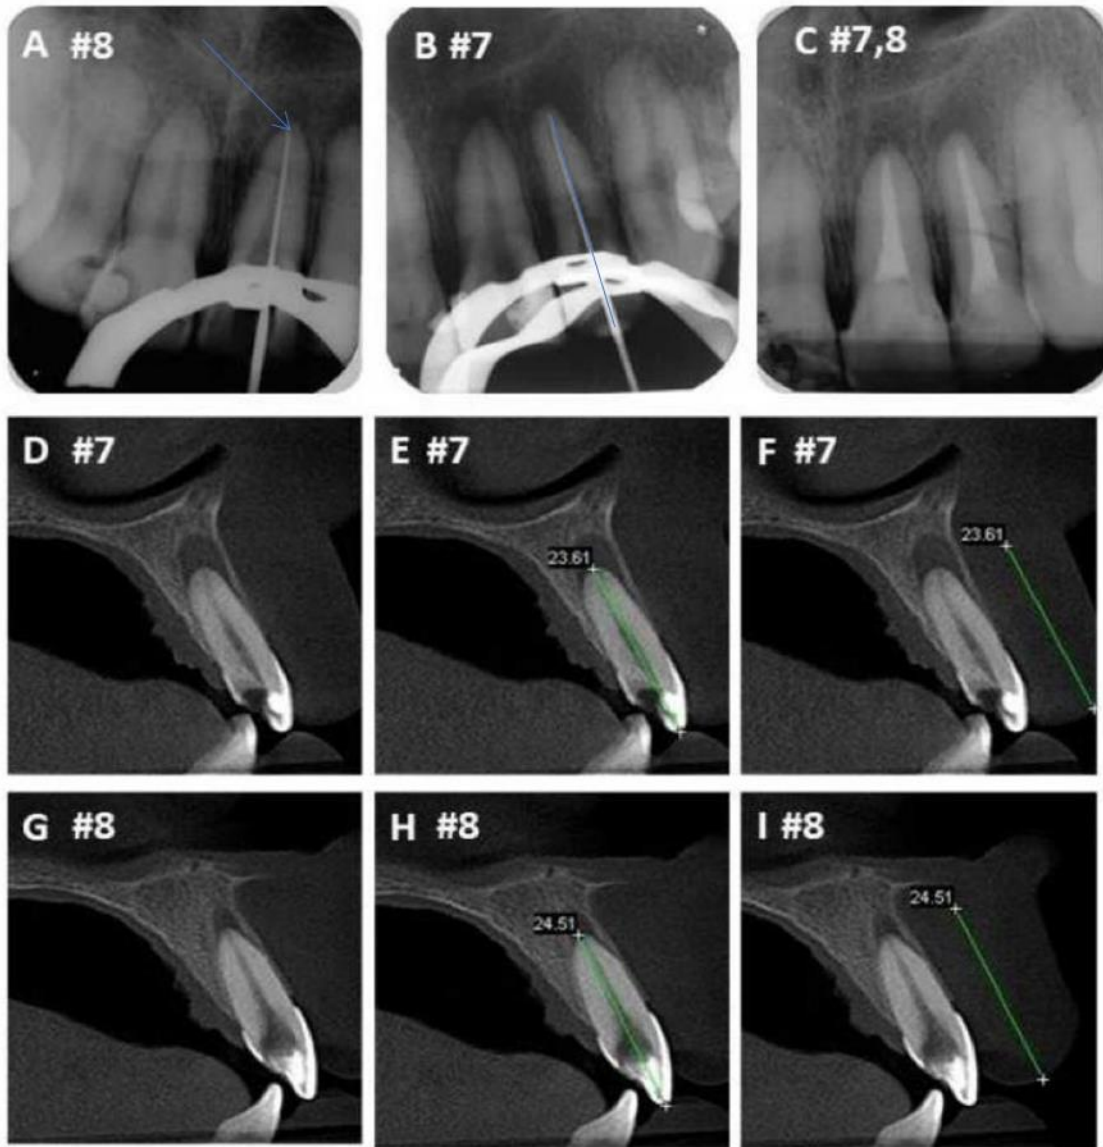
Determination of W.L. in upper and lower anterior teeth: A to C) periapical radiographs and D to I, the blue arrow in figure A refer to radiographic apical foramen while figure B refer to full W.L. from incisal edge to apical foramen) C.B.C.T. images.
